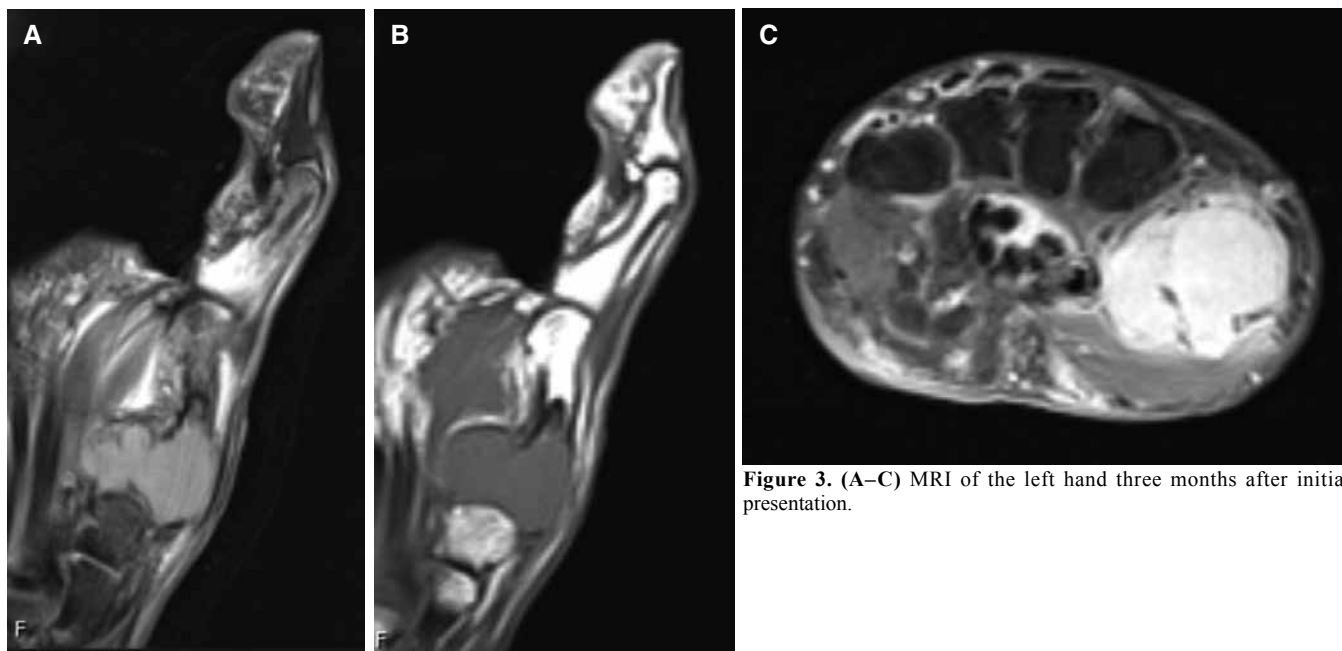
(A–C) MRI of the left hand three months after initial presentation.
